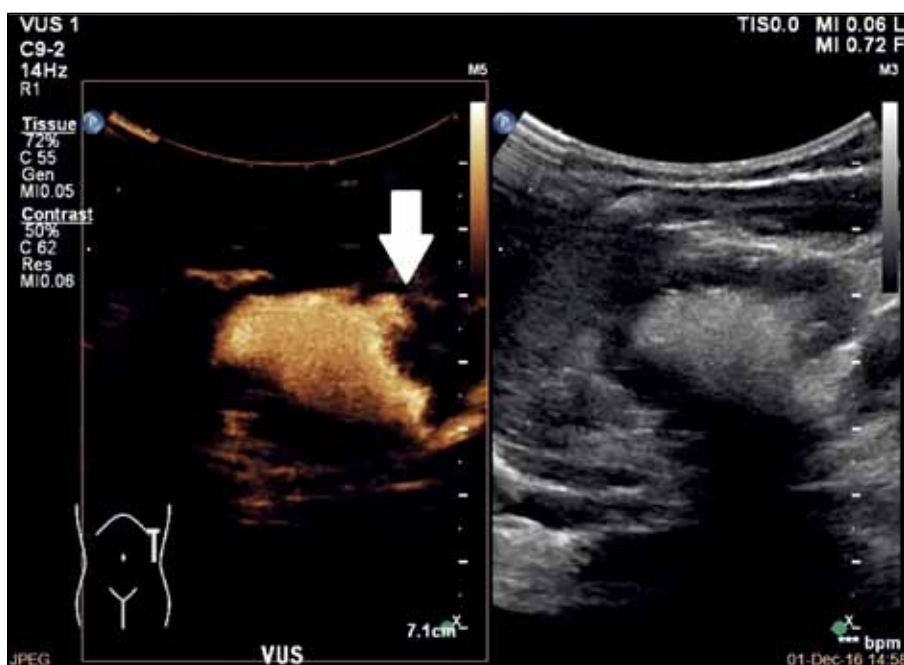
Patient A. Longitudinal contrast-enhanced voiding urosonography scanning over the left renal region. Contrast-specific harmonic imaging (left) and fundamental greyscale imaging (right) showing highly echogenic microbubbles present within dilated lower moiety pelvicalyceal system with blunting of renal calyces (white arrow), suggesting grade 5 vesicoureteric reflux.
